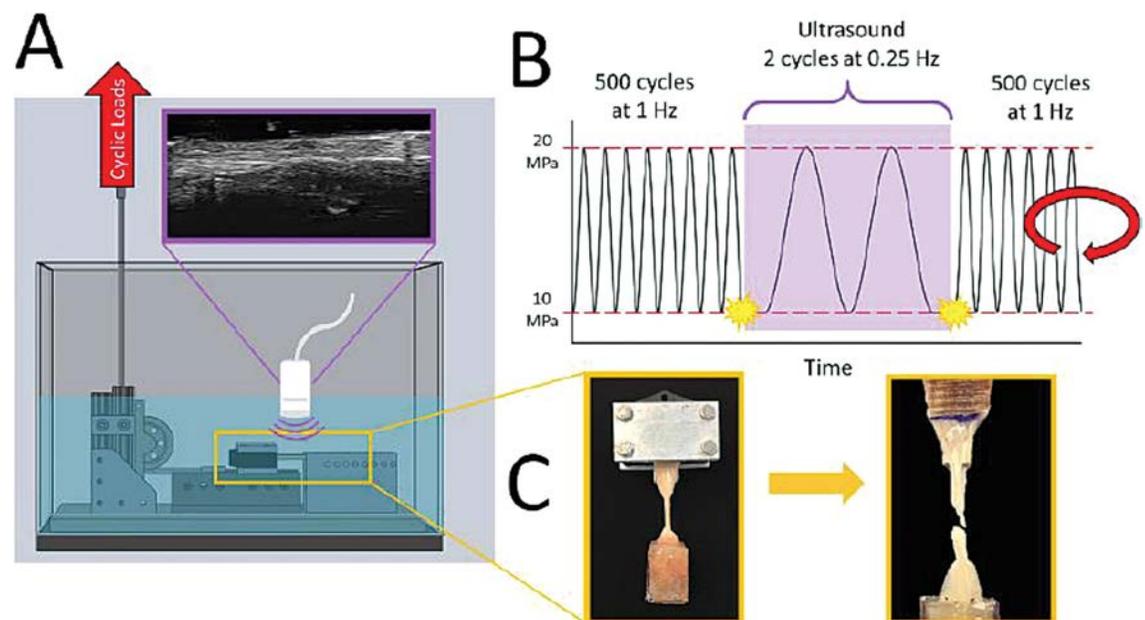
(A) Computer-aided representation of tank water bath testing setup, showing pulley, linear track, and tendon carriage setup. (B) Cyclic testing protocol applied to tendon. Ultrasound (purple) was captured every 500 cycles and initiated via a trigger signal (yellow bursts). (C) This protocol was repeated until tendon failure or until 150,000 cycles was achieved.
